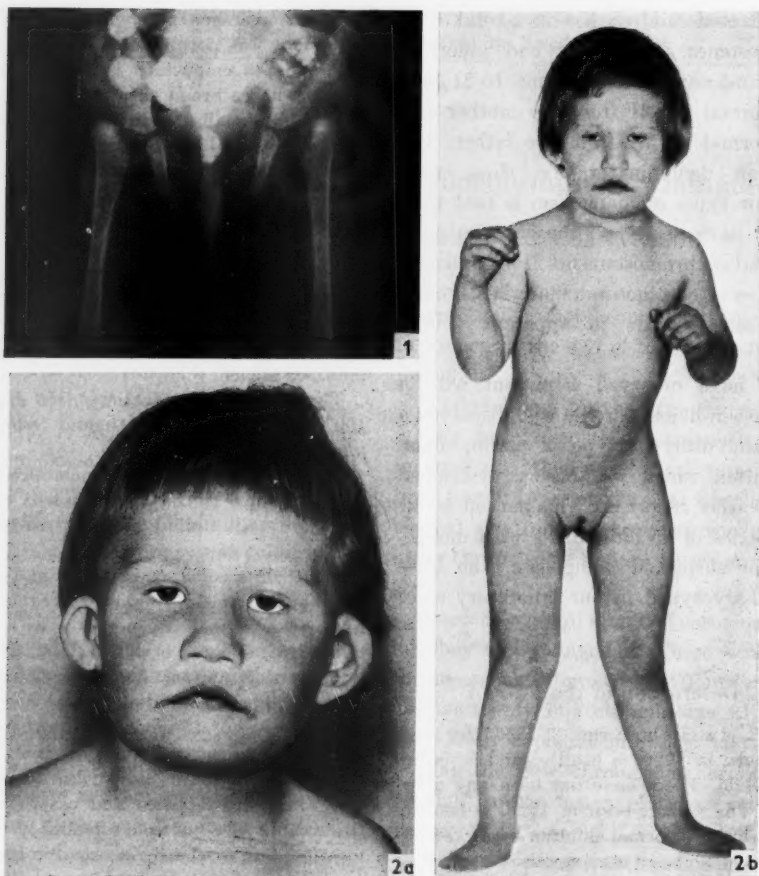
Roentgenogram of the patient's hip joints.
